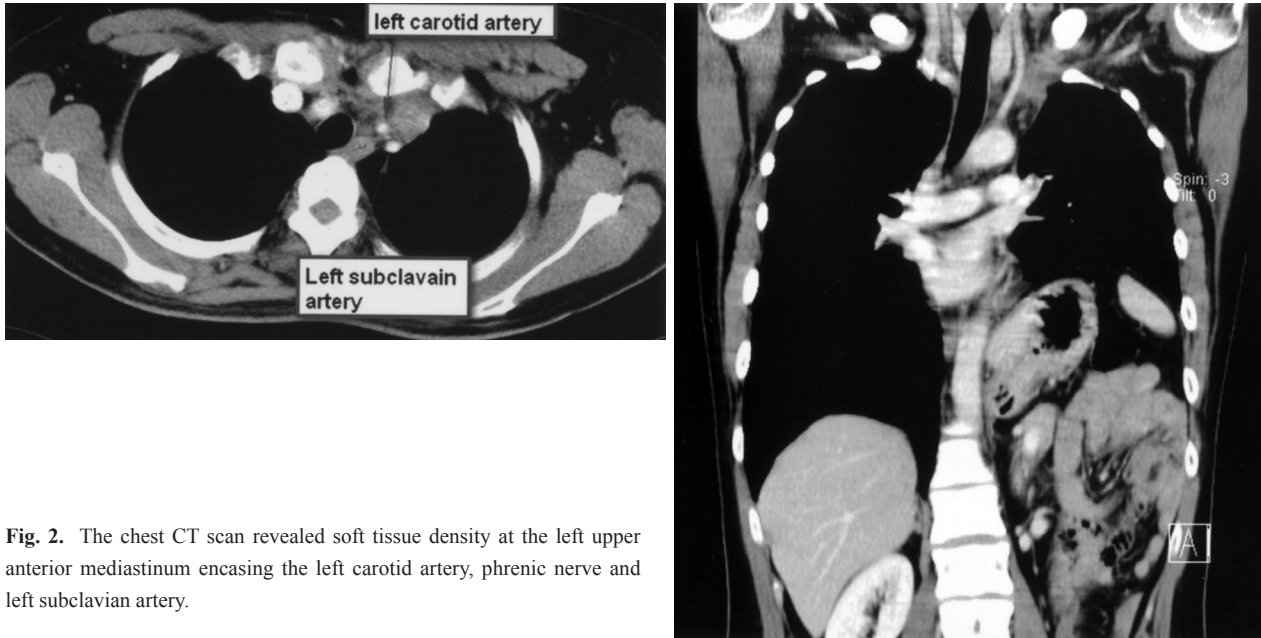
The chest CT scan revealed soft tissue density at the left upper anterior mediastinum encasing the left carotid artery, phrenic nerve and left subclavian artery.
